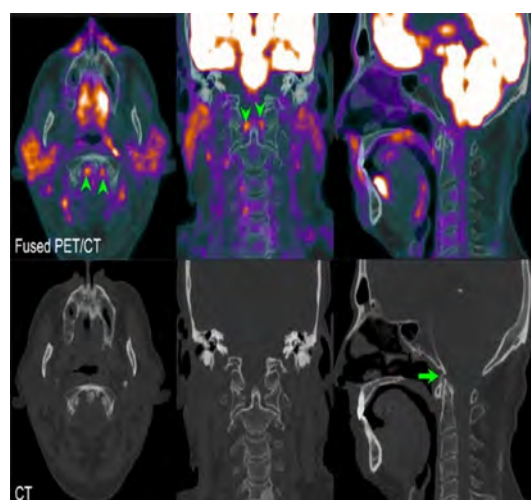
Changes in atlanto-axial articulation. Fused ^{18}F -FDG PET/CT sections (top row) and their corresponding low-dose CT (bottom row) extracted from TB-PET/CT for a 62-year-old man with PsA in axial (left), coronal (middle) and sagittal (right) views. Images demonstrate intense FDG uptake with rSUVmax 1.7 at the alar ligaments (arrowheads) with evidence of ossification of the anterior atlanto-occipital membrane on the CT (arrow).
